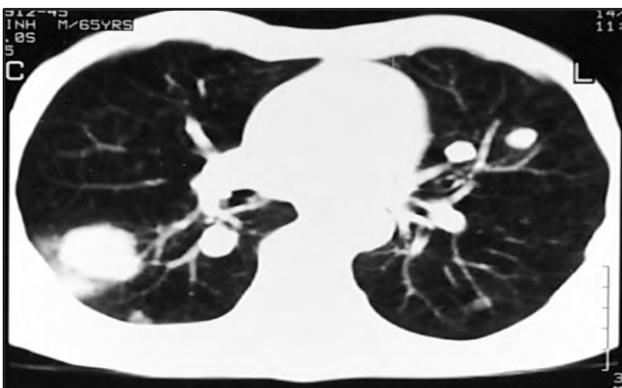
Axial contrast enhanced computed tomography (CECT) image at right pulmonary artery level in lung window settings reveals multiple soft tissue density lesions in both lung fields.
